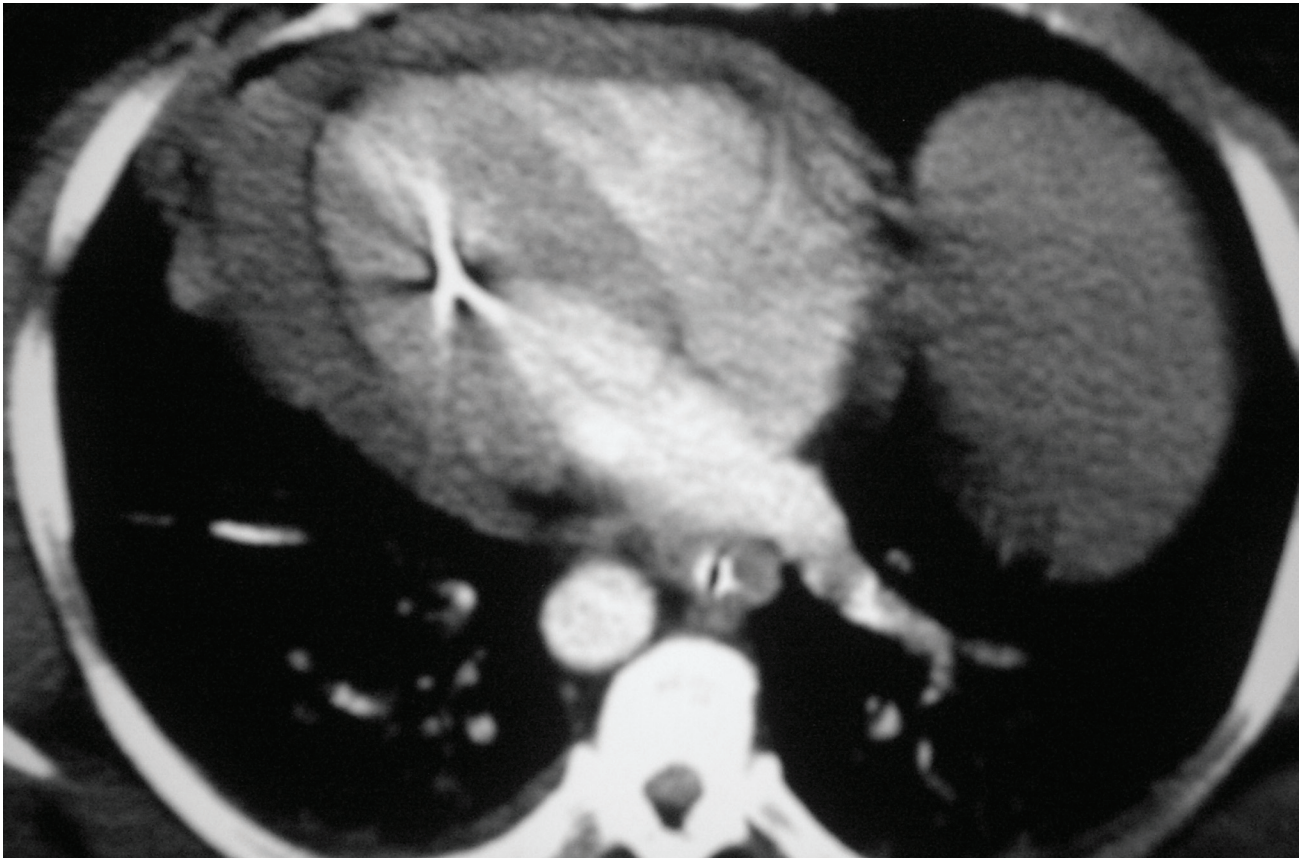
Chest CT image (mediastinal window) showing metallic fragment in the heart with surrounding pericardial effusion.*
